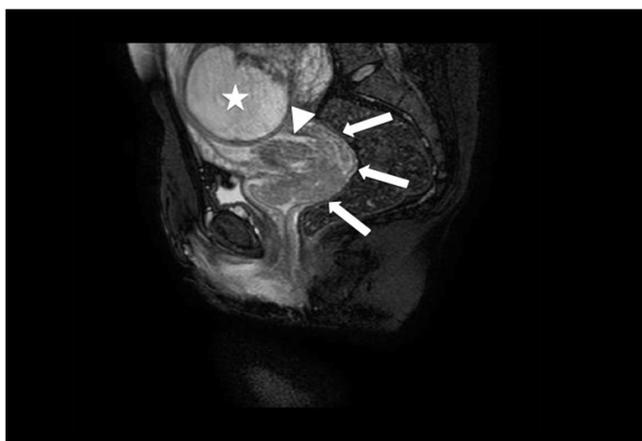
Sagittal T2 weighted MR image shows cervical carcinoma invading the cervical stroma and posterior fornix of the vagina (arrows). Upper part of the cervical canal (arrow head) can be normally seen. Fetal head (asterix) is located beside the cervix
